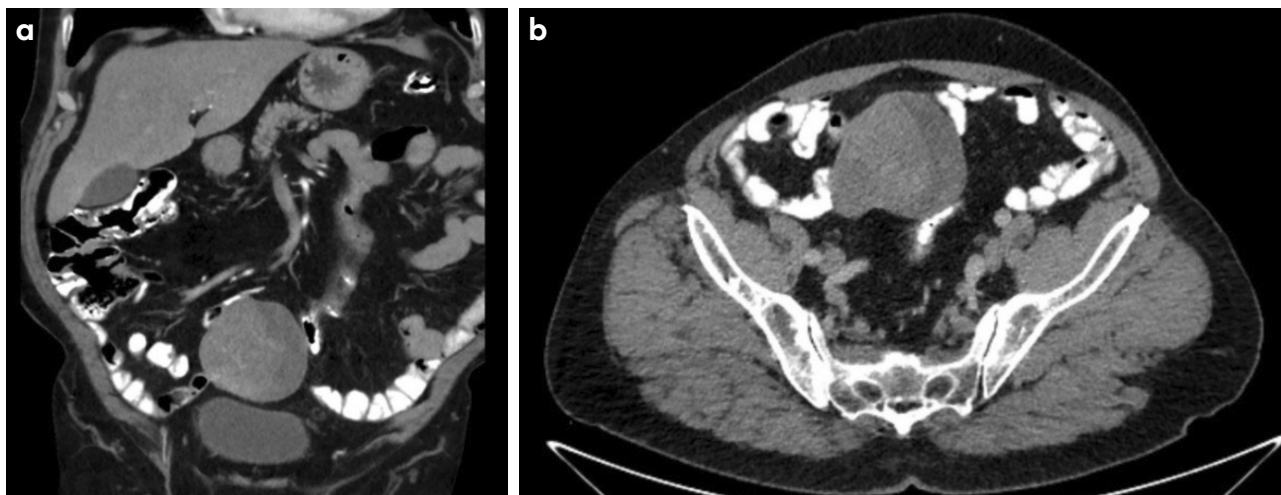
a, b. Sagittal and transverse computed tomography scans of a 67-year-old woman showing a 5 × 6-cm gastrointestinal stromal tumour (arrows) with origin from the jejunal wall, closely related to but not infiltrating the mesentery.
